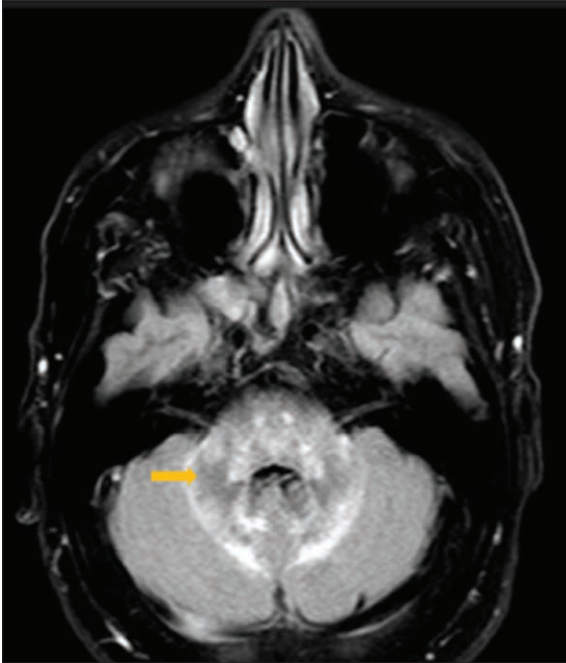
Brain magnetic resonance imaging: hyperintense lesions in T2/FLAIR at the cerebellum, medulla oblongata.
